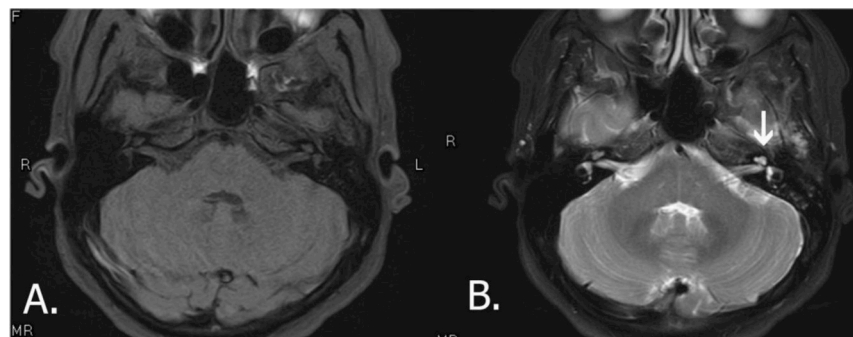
MRI with contrast of the temporal bone. A) T1 weighted axial view; B) T2 weighted axial view, fat suppression. There was mild enhancement of the left vestibule and basal turn of the left cochlea (arrow) and enhanced hyper signal intensity of the left mastoid. No additional abnormalities were found in the post-contrast image.
